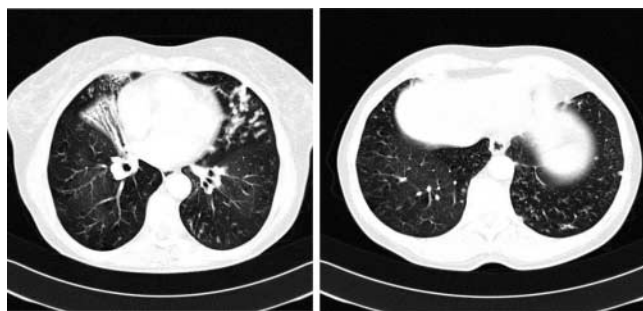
High-resolution computed tomography of the lungs (05.02.2011). Partial loss of volume in middle lobe with bronchiectasis. Multiple mucous plugs in small lingular bronchi. Ill-defined centrilobular nodules are visible in both lower lobes
